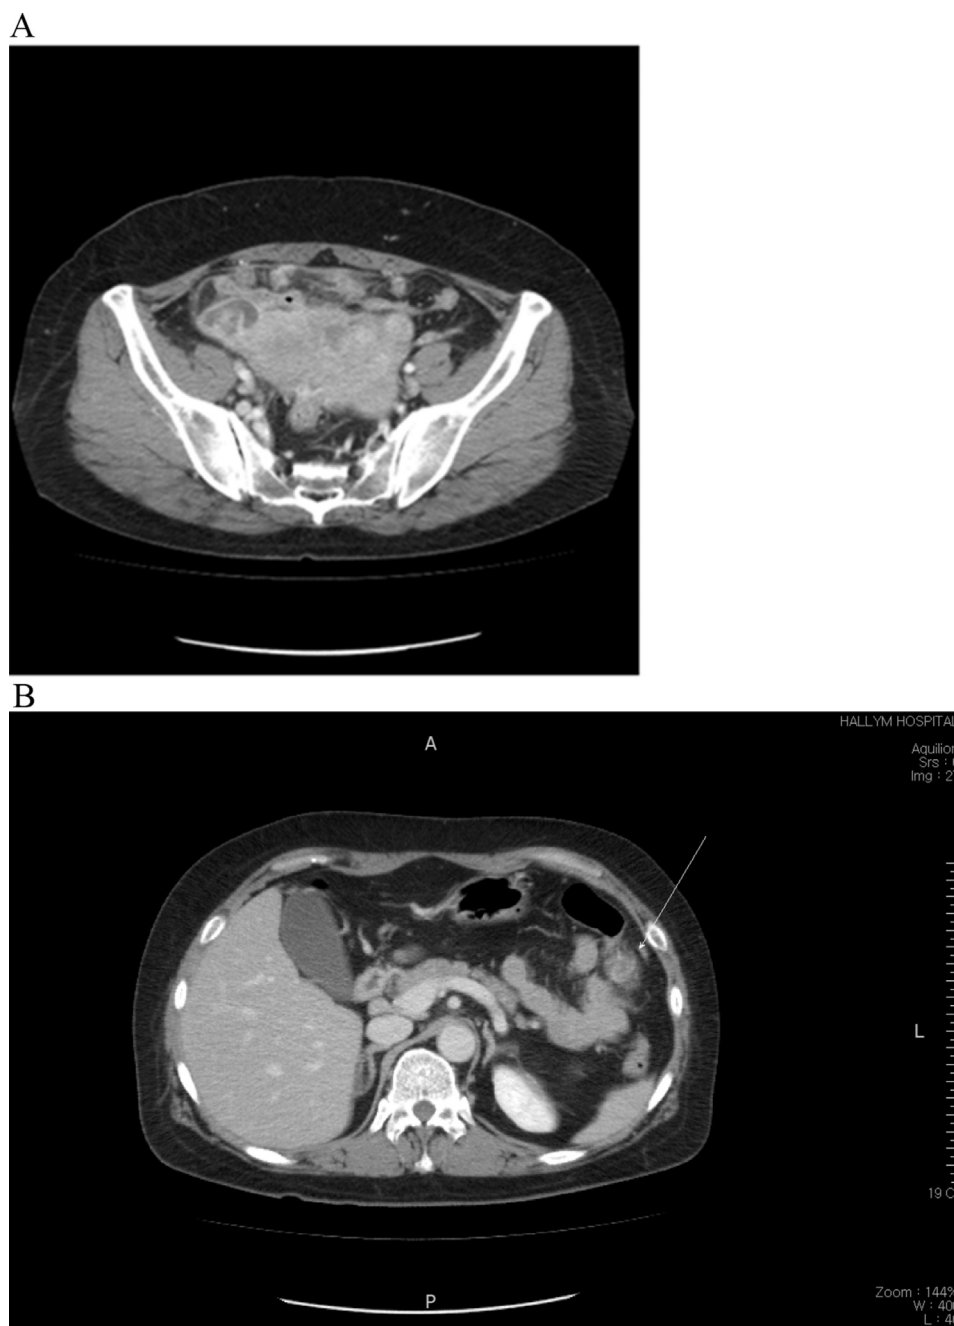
Computed tomography of the abdomen with contrast enhancement shows that (A) the uterus is enlarged with multiple myomas and the cecum has edematous wall thickening, fluid collection, and severe fat infiltration; and (B) the arrow shows the location of the omental actinomycosis.
